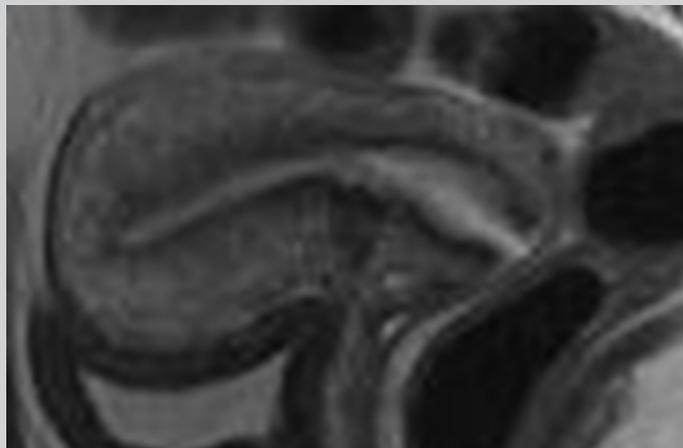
MRI image of IUD in uterus.
